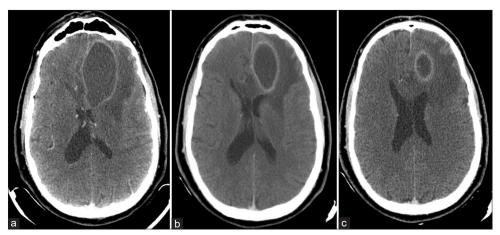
Computed tomography (CT) scan of the brain (axial images) revealing a large intracranial abscess-associated mass effect. (a) Initial CT scan, (b) after the first aspiration, and (c) after the second aspiration.
